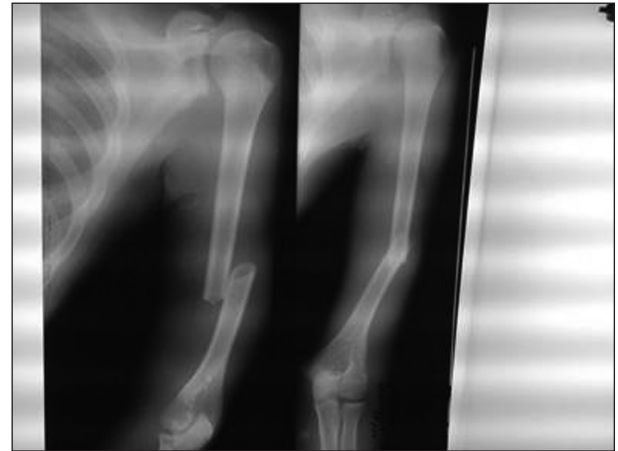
Pre-operative radiograph of fracture shaft of humerus
